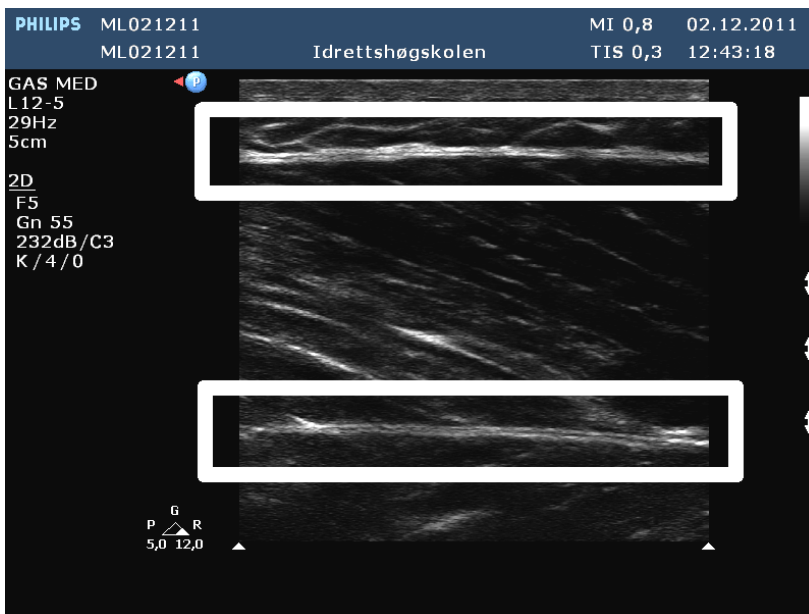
B-mode ultrasound image of the vastus lateralis muscle, with the deep and superficial aponeurosis marked.
